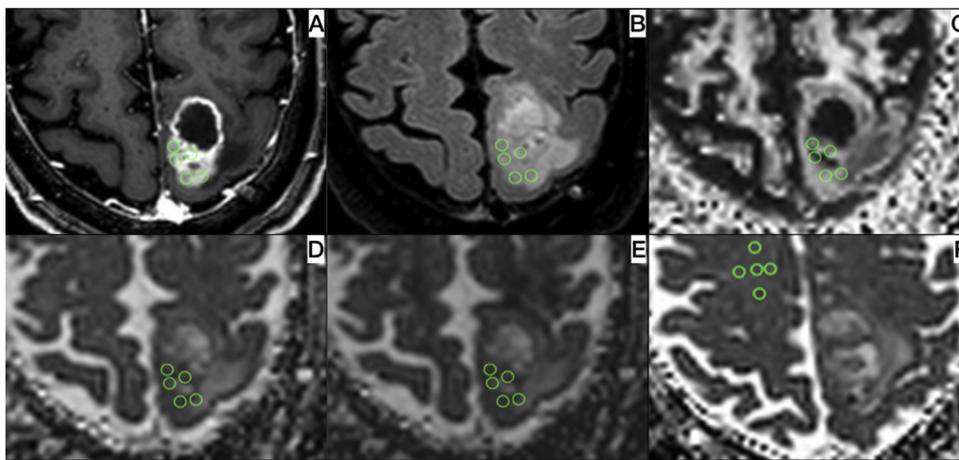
3T MR Axial images and parametric maps in a patient with left parietal HGG. A-E: 5 ROIs placed on tumor tissue in left parietal lobe; A: T1-weighted axial image, after Gadolinium administration; B: axial FLAIR image; C: FA map; D: MD map; E: RD map; F: 5 ROIs placed on contralateral (right) SOC, in the same patient, MD map.
